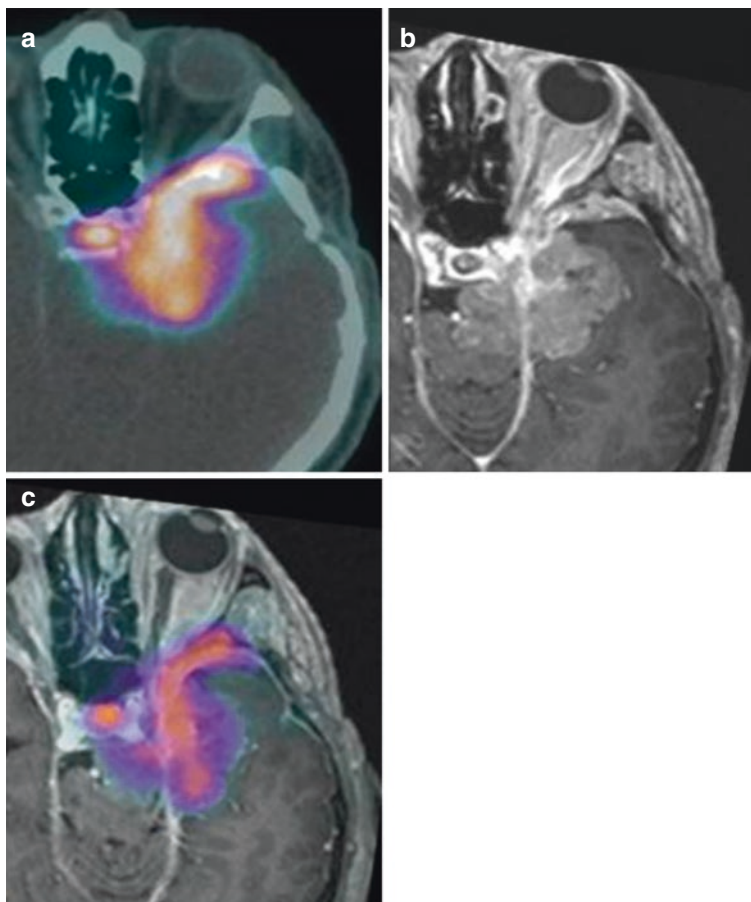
Meningioma with close proximity to the pituitary gland in a patient who is a candidate for radiotherapy. PET/CT (a) demonstrates a ^{68}Ga -DODATATE avid lesion in the left middle fossa. The MRI (b) shows higher anatomical details. PET/MRI allows visualization the exact extension of the disease. A pituitary sparing field of irradiation was chosen after the precise information provided by PET/MR scan. ^{68}Ga -DODATATE avidity in the pituitary is physiological [1]
